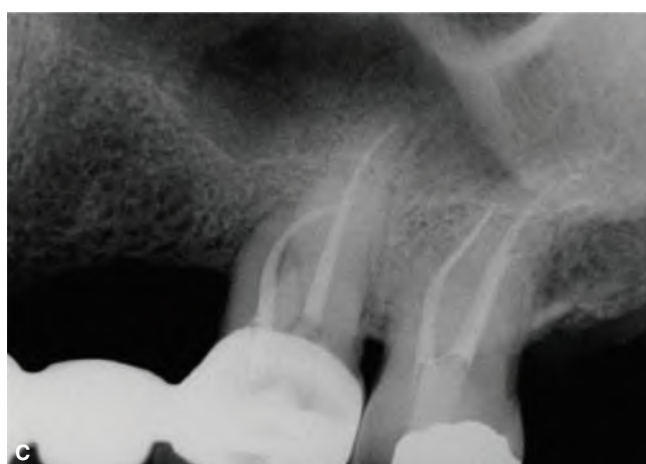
Medical contra-indication to extraction. A. Preoperative bitewing radiograph of a symptomatic supra-erupted maxillary left second molar in a 83-year-old male with a history of a recent open heart surgery. Although non-functional, the tooth was treated endodontically. B. Preoperative periapical radiograph. C. Postoperative radiograph. Following treatment, the patient was asymptomatic.
